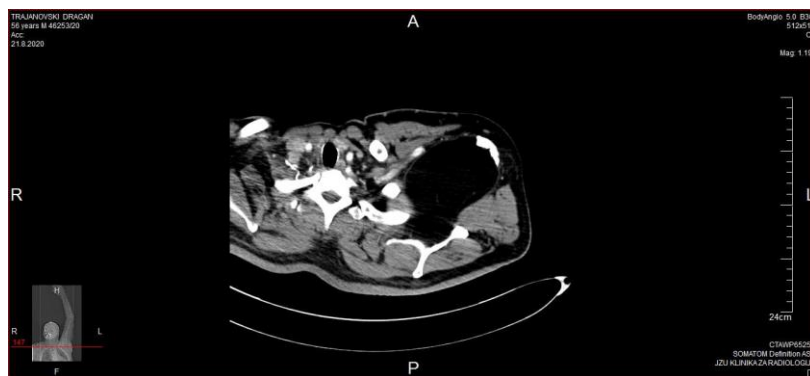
A CT scan angiography depicted encapsulated, hypodense and oval image measuring 15x9x8cm mass strongly indicative for lipoma
